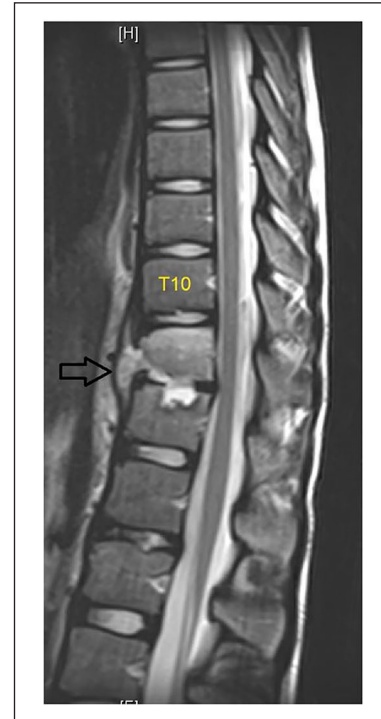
Sagittal MRI T2 shows abnormal signal and loss of the normal disc space at the T11–T12 level with destructive changes of the inferior endplate of T11 and the superior endplate of T12. In addition, there is fluid signal within the disc space extending anteriorly into the paraspinal space consistent with a tiny developing abscess (arrow).
